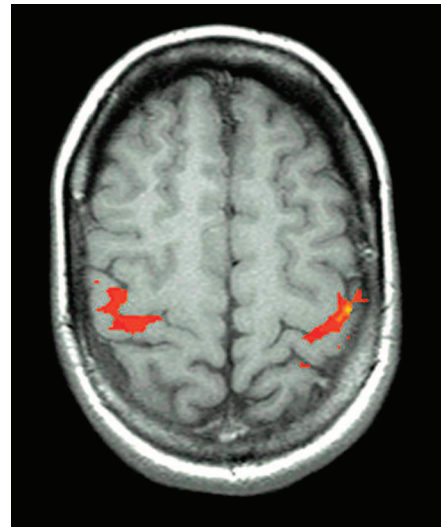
Functional MRI scan of the brain showing activity of the motor cortex during a bilateral finger-tapping task.
